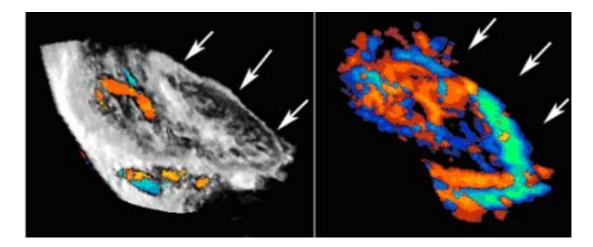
The three-dimensional color Doppler image of one transplanted kidney showing that the volume of inferior segment became small and the blood flow signals of inferior segment disappeared (arrows: inferior segment).
